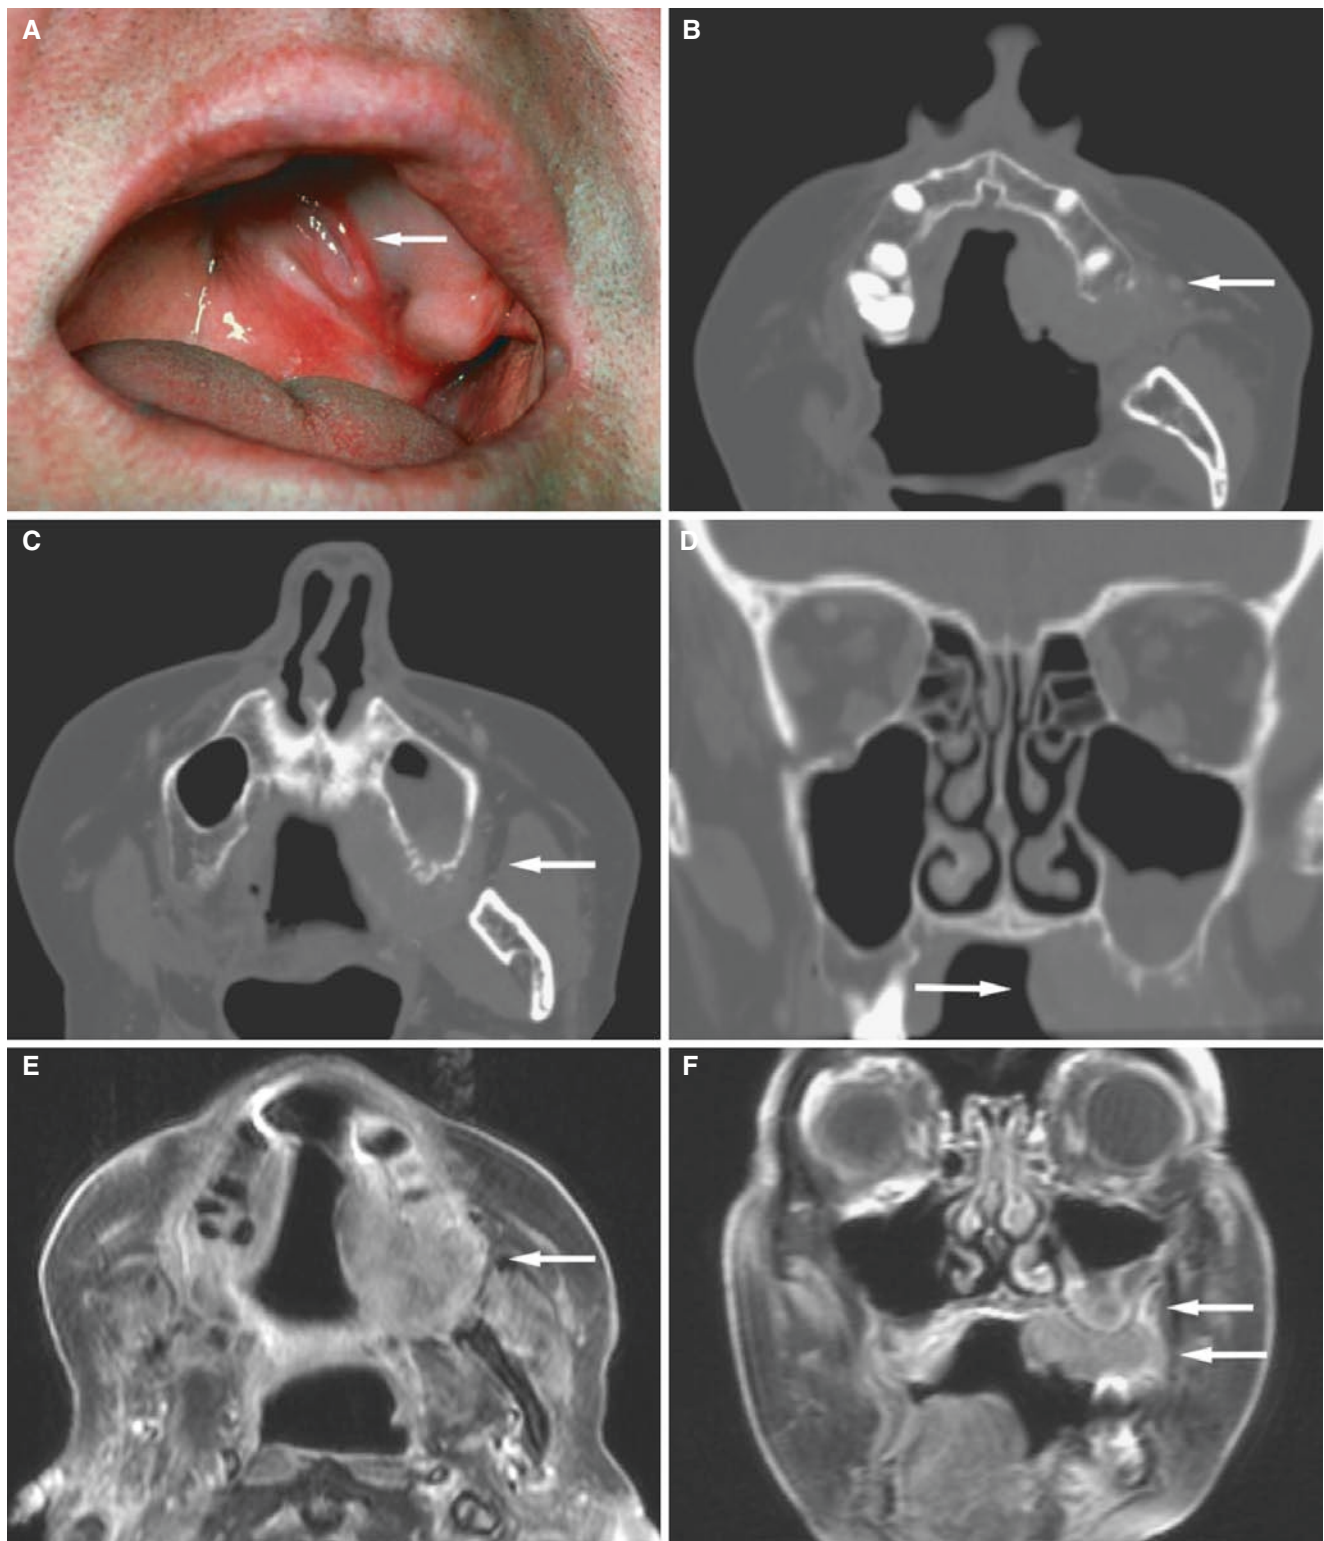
Squamous cell carcinoma of the left maxillary sinus; 80-year-old female with a 13-year history of successfully treated tongue cancer, now with mass in oral cavity. (A) Clinical photograph of another patient with the same diagnosis shows similar clinical picture; palatal swelling (*arrow*) posterior to complete denture (removed) as initial tumor sign. (B) Axial CT image shows destruction of the left maxilla and soft-tissue swelling (*arrow*). (C) Axial CT image shows intrasinus
